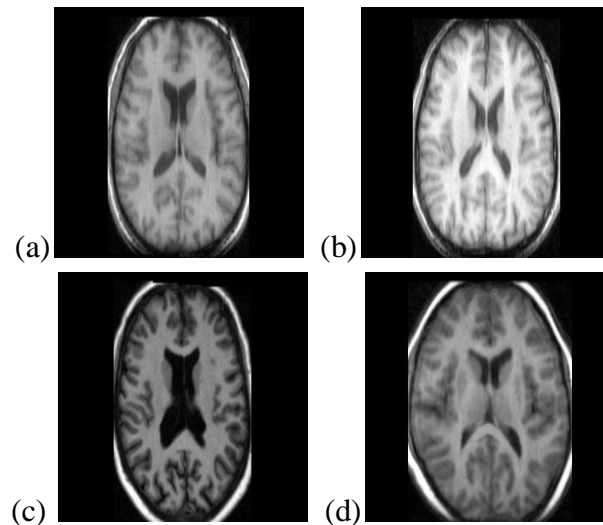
Healthy Brain MR images obtained from IBSR, T1-w image from subject a) IBSR_01, b) IBSR_06, c) IBSR_12, d) IBSR_18
